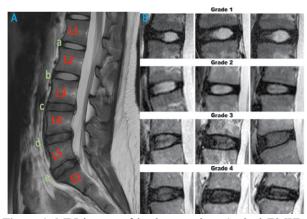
MRI images of lumbar vertebrae Sagittal T2-WI sequences (A), Grade I (b); Grade II (a); Grade III (c); Grade IV (d) and (e), Modified Pfirrmann Scale Grade 1 to IV(B)[8]
